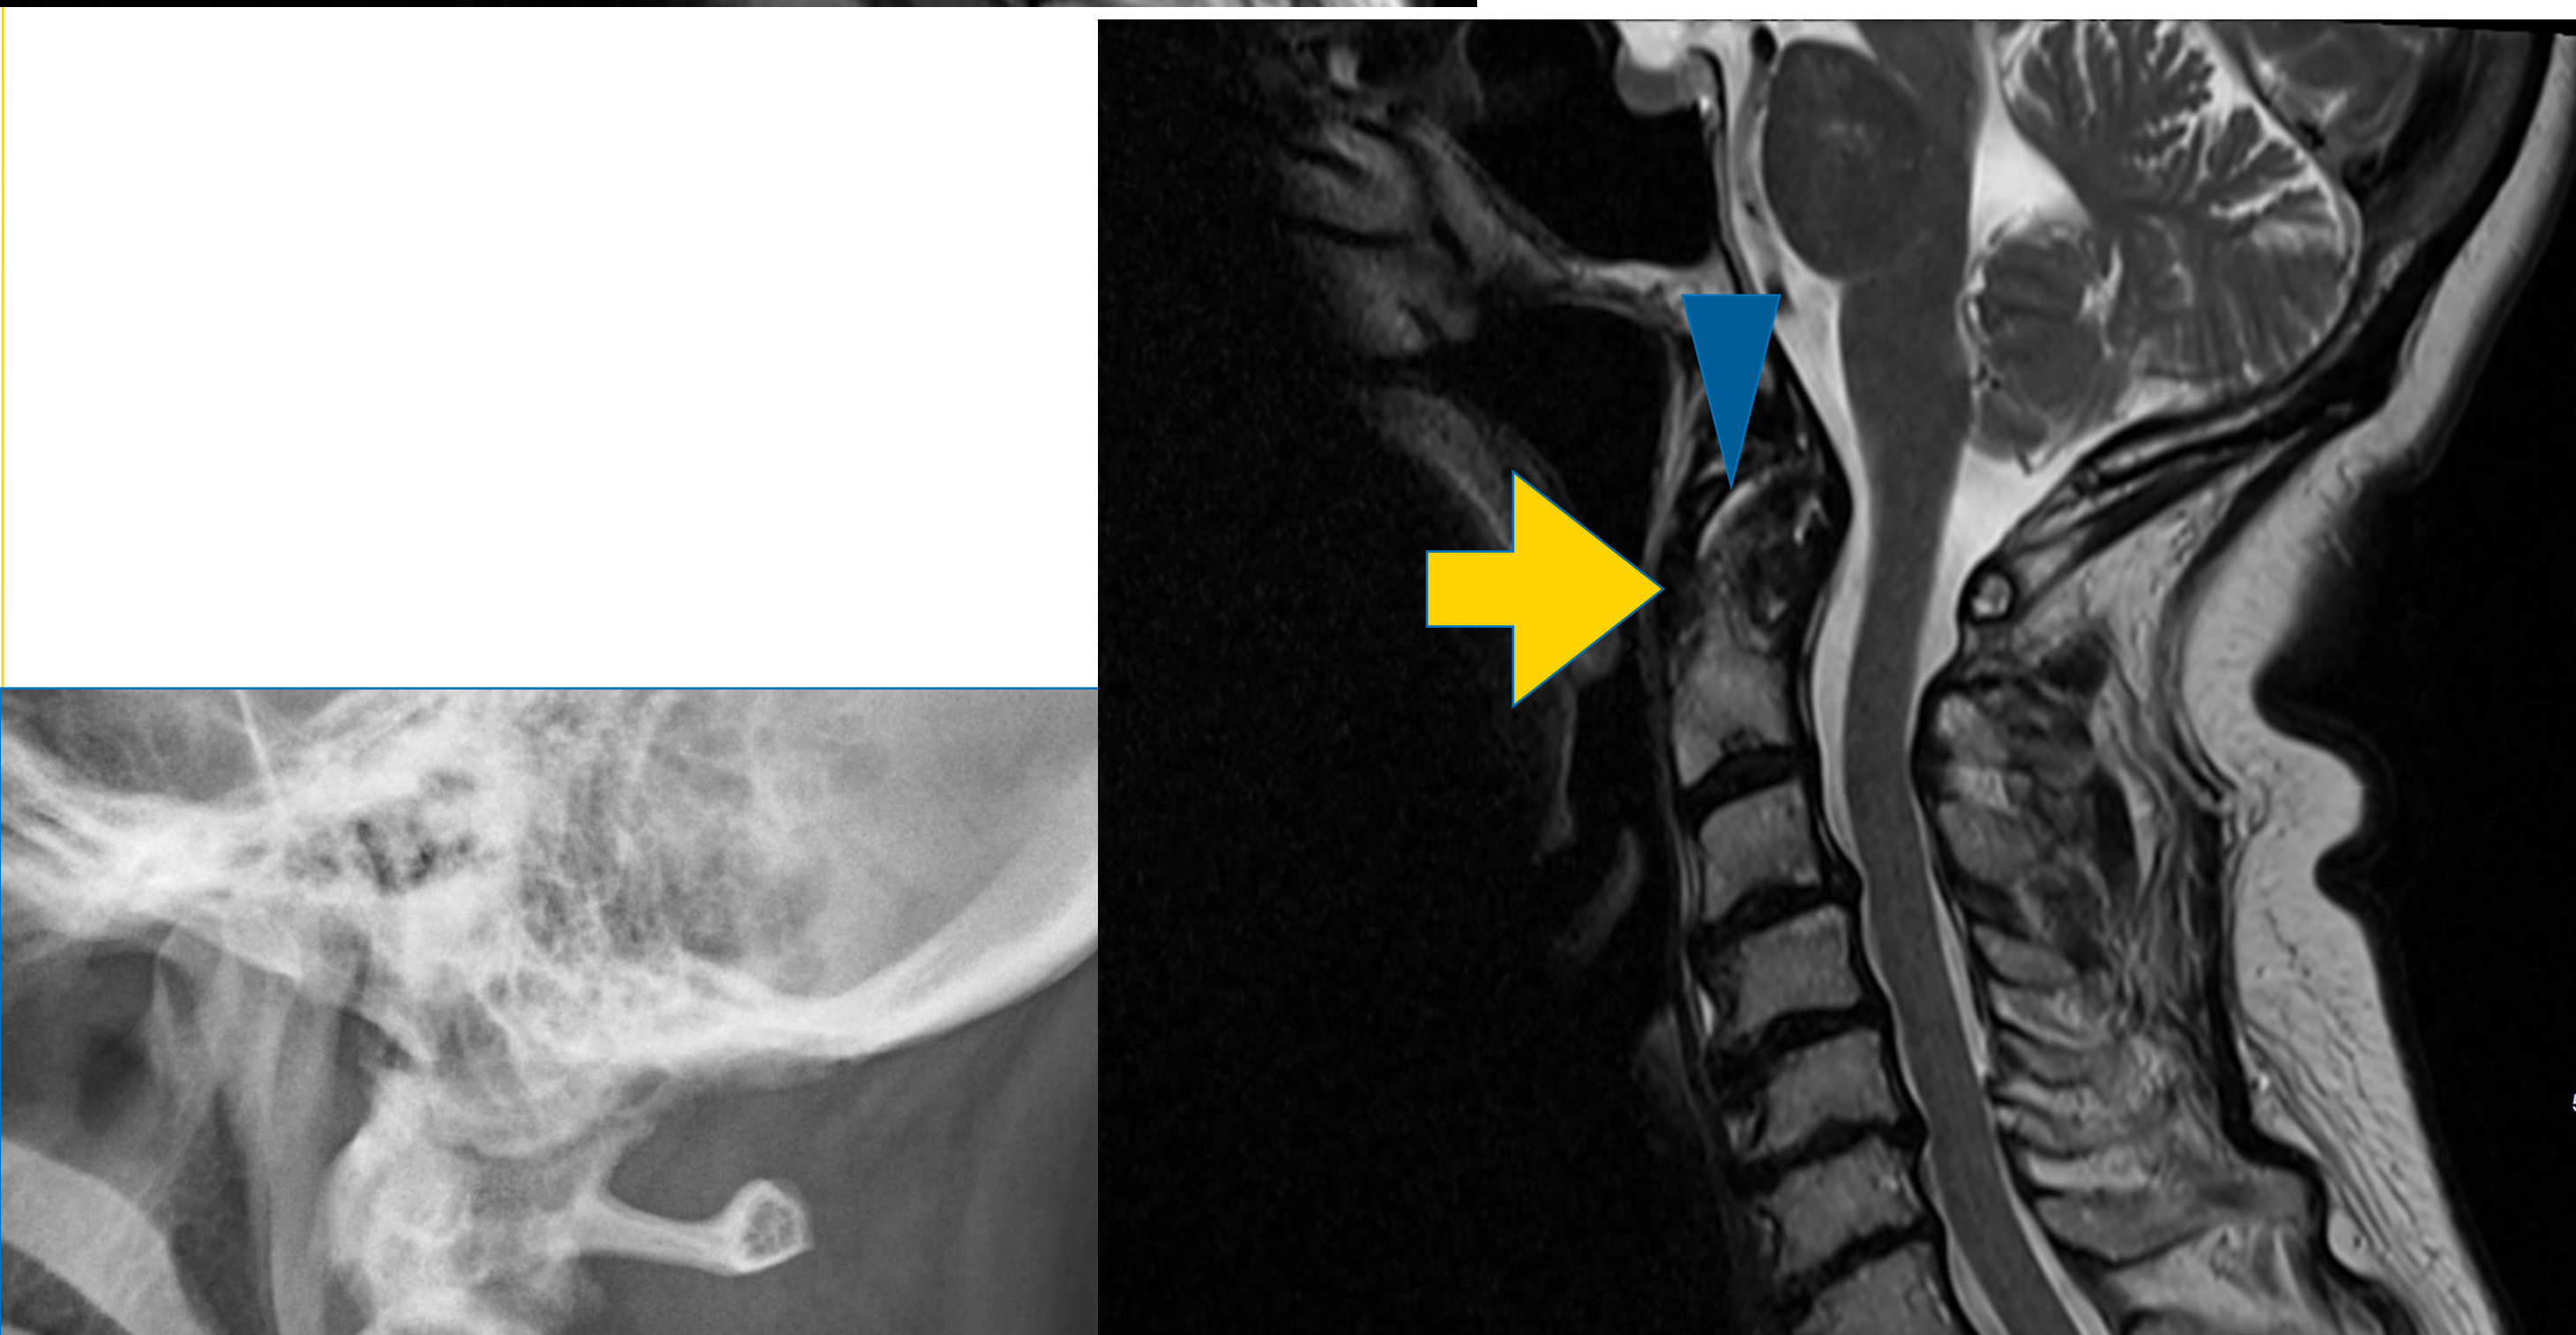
(left) C-spine X-ray: decreased C3-C7 disc spaces (blue arrows), disc disease with spurring, & facet arthropathy. Overall: marked degenerative discogenic & arthritic changes.
